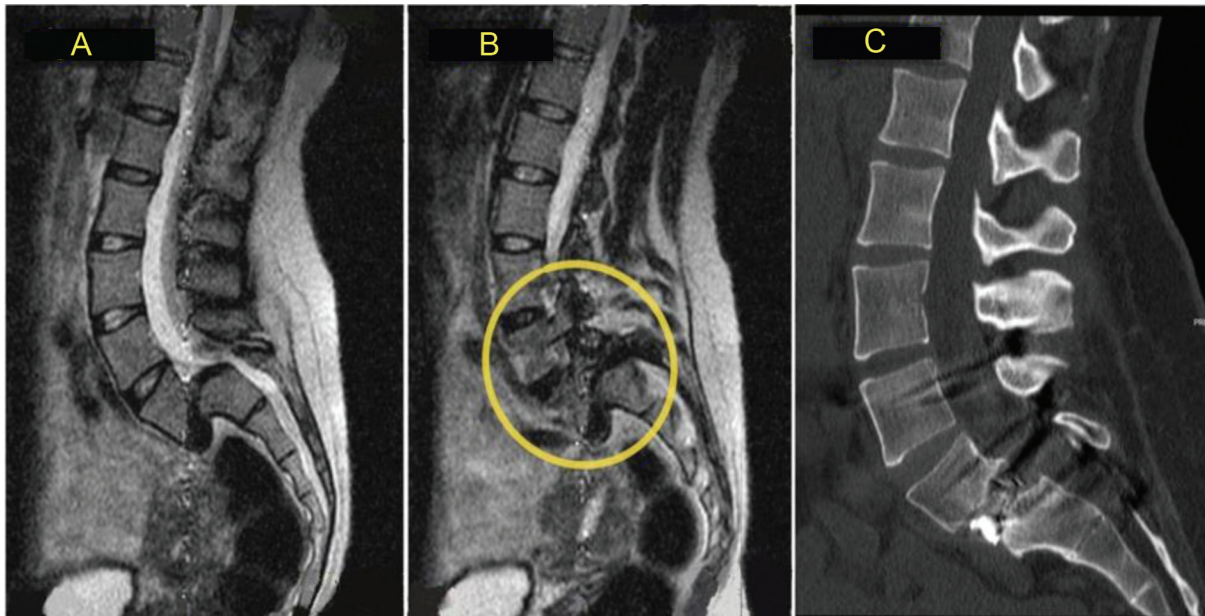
(A) Lumbar spine magnetic resonance imaging (MRI) with grade IV L5–S1 dysplastic spondylolisthesis. (B) The yellow circle shows the foraminal stenosis secondary to spondylolisthesis. (C) Postoperative computed tomography (CT) lumbar spine after minimally invasive surgery (MIS) reduction.
